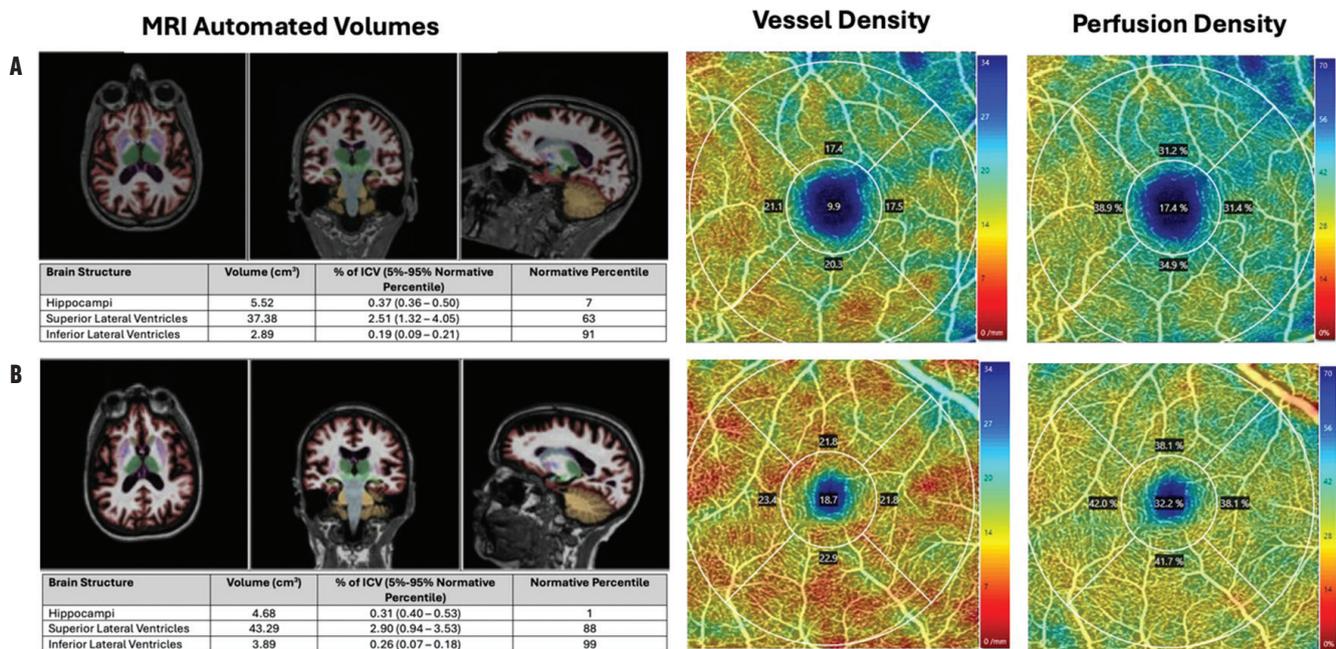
MRI and OCTA images of a patient with AD (A) and another with MCI (B). The OCTA superficial capillary plexus shows vessel density and perfusion density maps of the right eye. Reprinted from Zhao et al in accordance with the terms of the Creative Commons license ([creativecommons.org/licenses/by-nc-nd/4.0/](https://creativecommons.org/licenses/by-nc-nd/4.0/)).<sup>5</sup>
